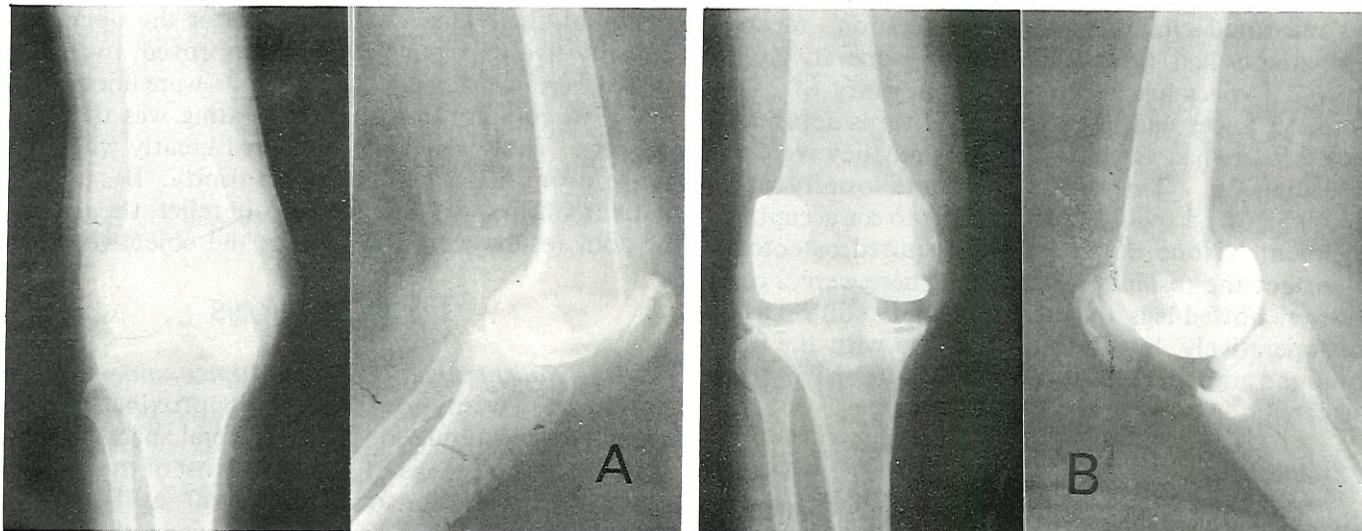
AP and lateral radiographs of the knee before the operation showing joint destruction from rheumatoid arthritis (a). Postoperative radiographs showed the geometric prosthesis in place (b). (Case 2)
